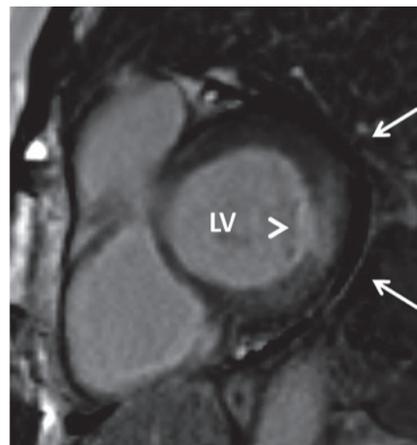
Cardiac magnetic resonance image of 68-year old patient with chronic and active rheumatoid arthritis. Short-axis views of the LV shows local, transmural late gadolinium enhancement of the basal lateral wall (arrow head). This patient exhibited also pericardial effusion seen as low (black) signal next to lateral wall of the LV (arrows). LV: left ventricle.
